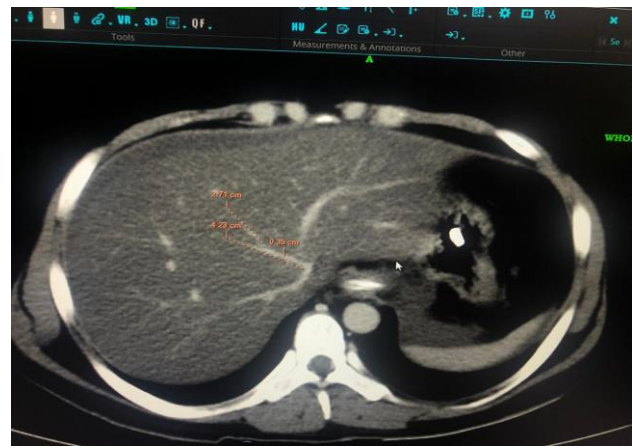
A CT image of 50 year male patient showing length and width of the middle hepatic vein.
